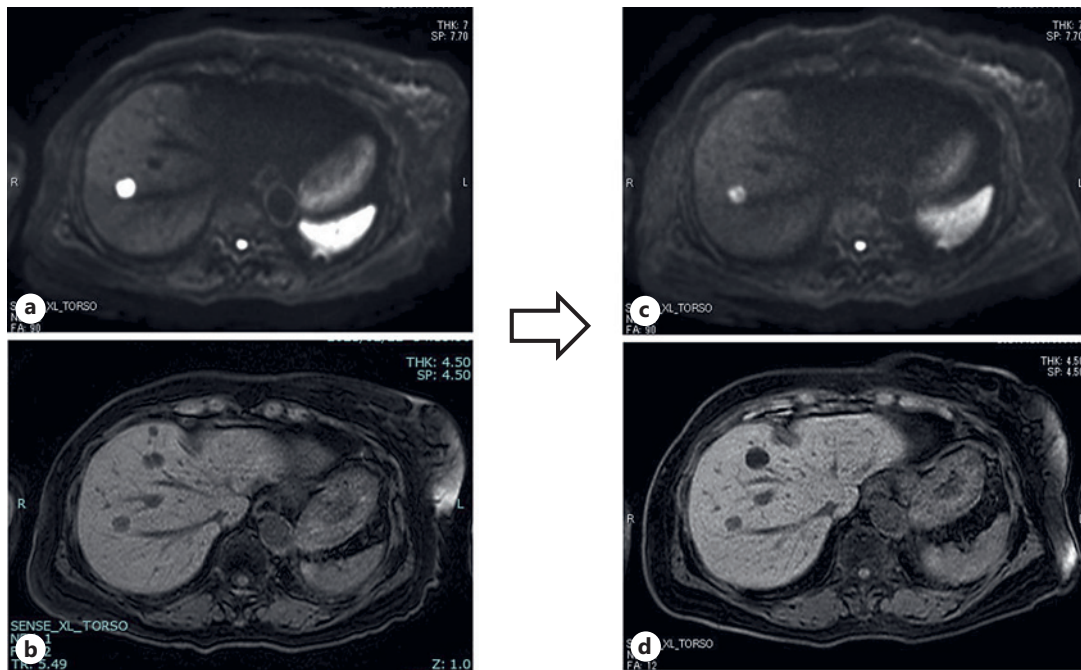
a, b. Magnetic resonance image (MRI) revealed a newly detected metastatic hepatic tumor. c, d. Follow-up MRI after 300 mg imatinib/day for 18 months following surgical treatment of rectal GIST led to metastatic hepatic tumor size reduction.
